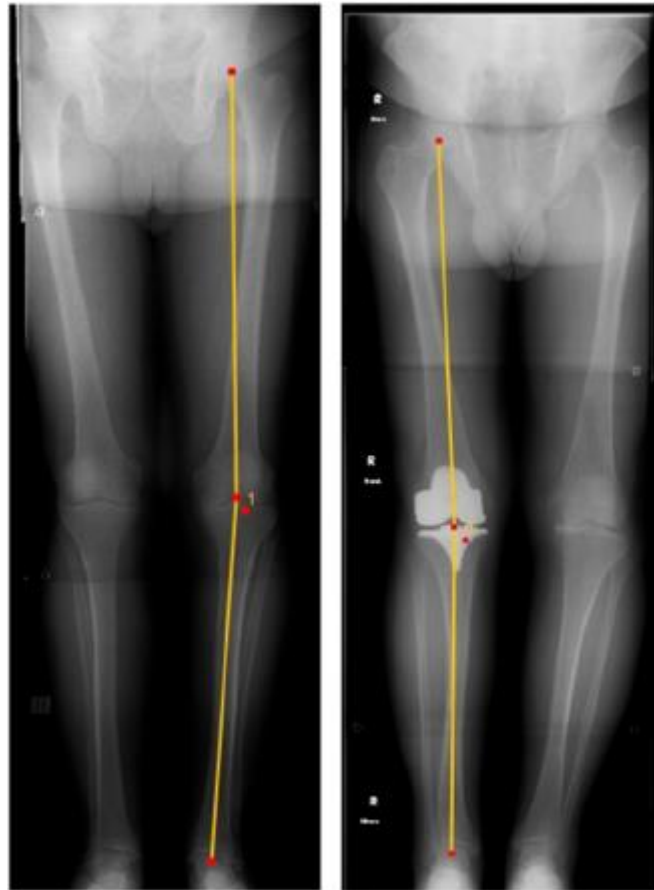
Example of Varus Mechanical alignment in a pre-op long leg x-ray and near 'Neutral' mechanical alignment post-op¹¹⁷
